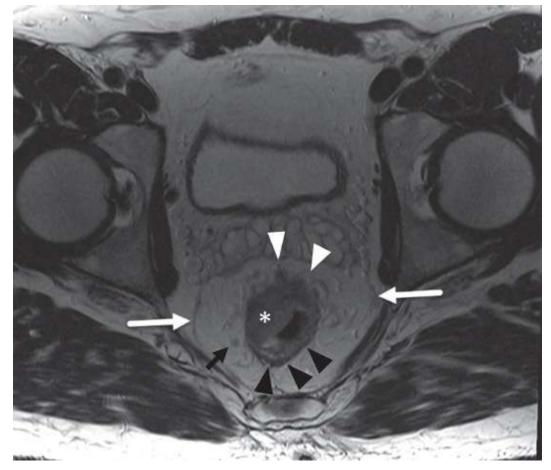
Pelvic MRI for rectal cancer: High-resolution, oblique axial, T2-weighted MRI image demonstrates a T2 hyperintense mass along the right and anterior aspect of the rectum (*), with nodular soft tissue extension (*white arrowheads*) through the T2 hypointense muscularis into the adjacent mesorectal fat. Normal T2 hypointense muscularis is seen along the posterior aspect of the rectum (*black arrowheads*). The findings are indicative of a T3 cancer. A small, indeterminate mesorectal lymph node is seen at the 8 o'clock position (*black arrow*). The circumferential resection margin is not involved (*white arrows*).
